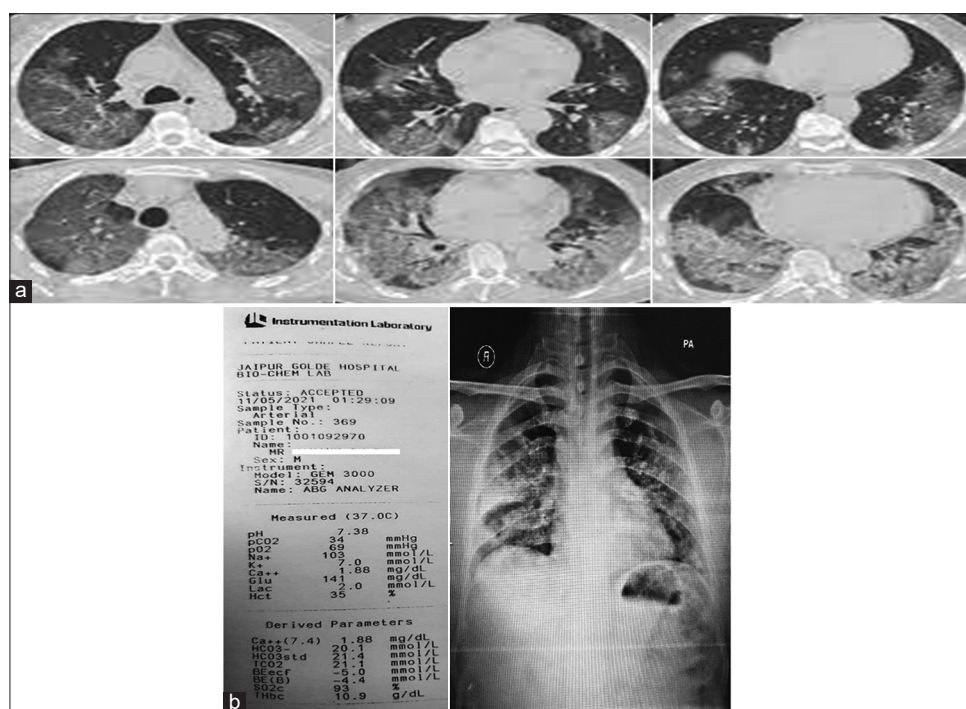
(a) High-resolution computed tomography (CT) chest of patient with CT severity score of 18/25 as on day 8. (b) Arterial blood gas and chest X-ray of patient as on day 8.
